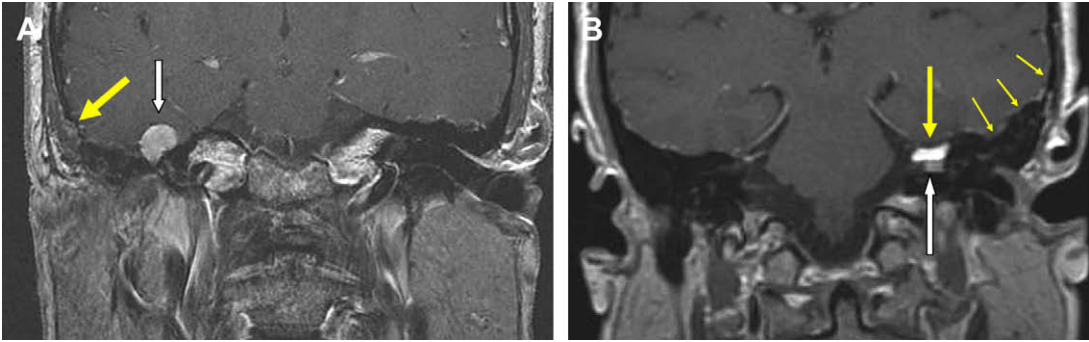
(A) Coronal T1-weighted postcontrast image demonstrates subtle findings consistent with middle cranial fossa surgery. There is a small calvarial defect (yellow arrow) with moderate atrophy of the temporalis muscle. There is minimal change to the floor of the middle cranial fossa. Note the enhancing mass (white arrow), a recurrent facial nerve tumor at the geniculate ganglion level. (B) Coronal postcontrast T1-weighted image in a patient after middle cranial fossa surgery for acoustic schwannoma. Note fat filling the defect in the roof of the IAC (large yellow arrow). Postoperative change along the floor of the middle cranial fossa is minimal (small yellow arrows). The craniotomy defect is small and there is temporalis muscle atrophy. Note enhancement in the IAC (white arrow) from residual tumor (proved subsequent to this examination by interval growth).
